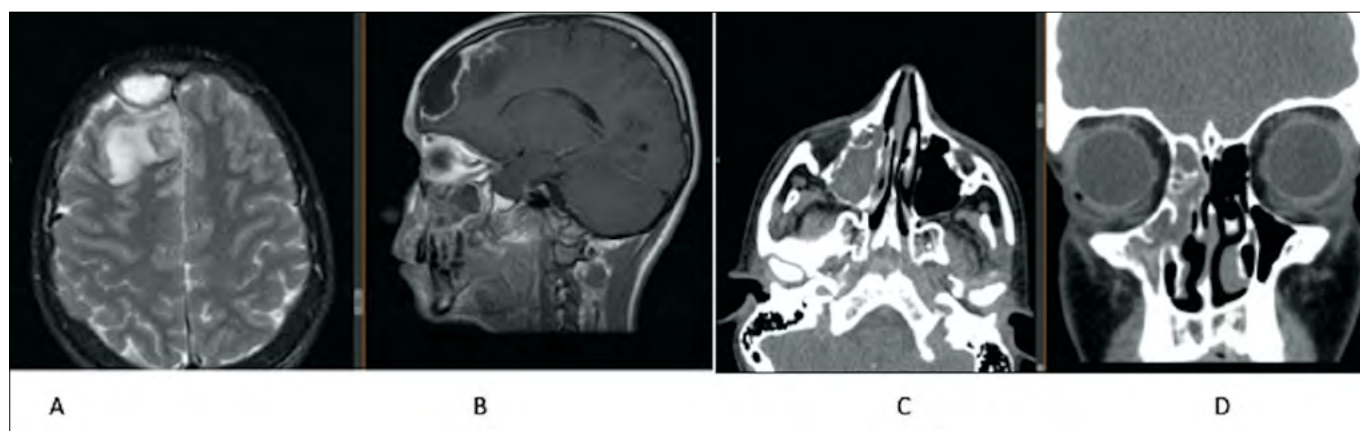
(A-B) MRI showing subdural empyema of right frontal lobe; (C-D) CT showing frontal-ethmoidal-maxillary right sinusitis.
